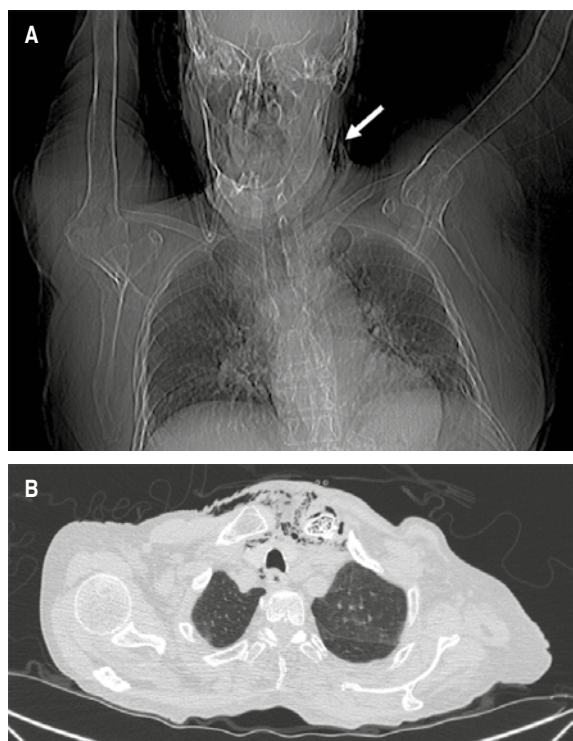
A) Topogram showing the presence of air in the left cervical region (white arrow). B) Computed tomography showing pulmonary window with evidence of retrotracheal air and subcutaneous emphysema.
